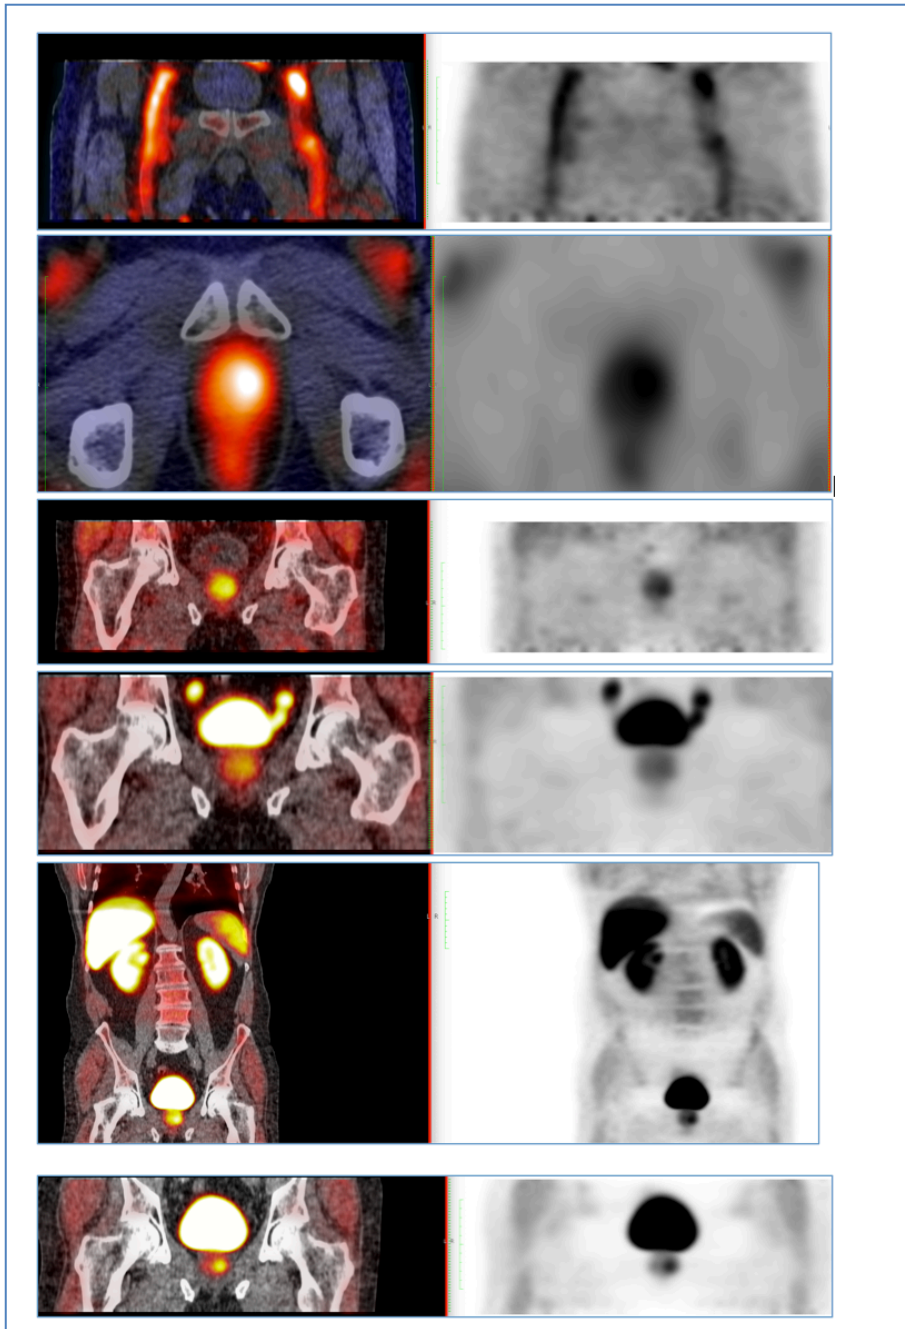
Fused PET & CT (left side) and PET reconstruction from top to bottom demonstrating flow to tracer in the vessels, perfusion to the prostate before the tracer has entered urinary bladder, excretion into the urinary bladder and prostate tracer retention on 60 minutes whole body and 90 minutes pelvic images.
